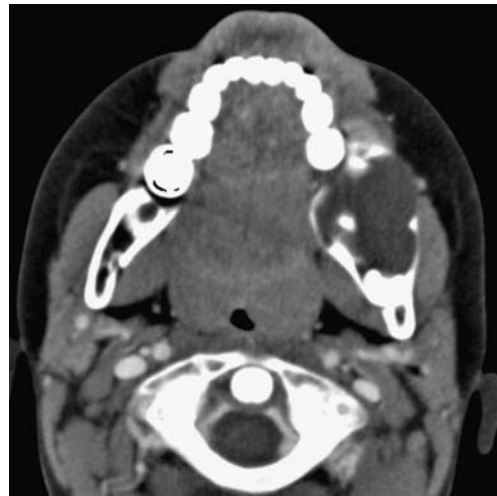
Contrast-enhanced CT image
